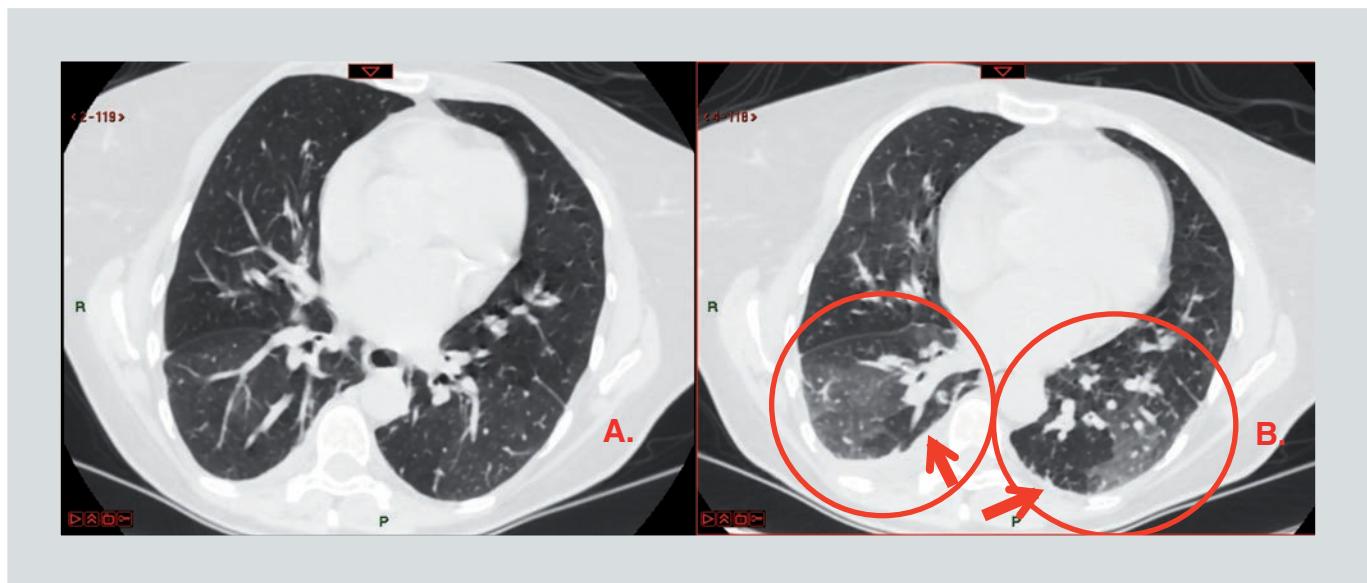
HRCT detection of gas trapping. A) Inspiratory CT sequence. B) Expiratory CT sequence (bronchodilators withheld by more than 12 hours) showing low lung attenuation areas (see arrows). CT: computed tomography; HRCT: high resolution computed tomography.
